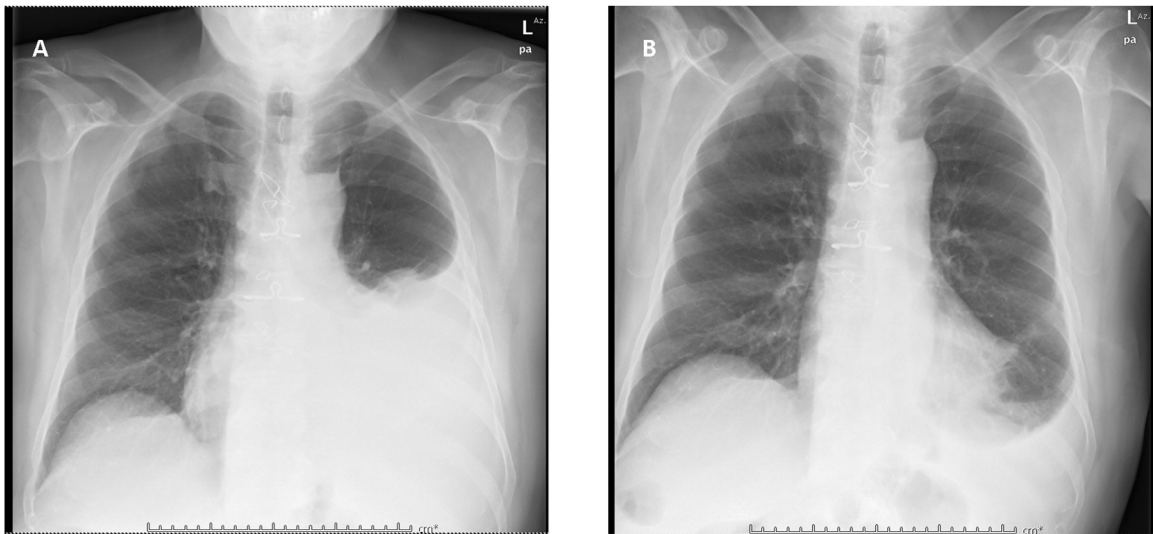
A. Chest radiograph at admission. B. Chest radiograph at discharge after talc poudrage in association with subcutaneous octreotide.
